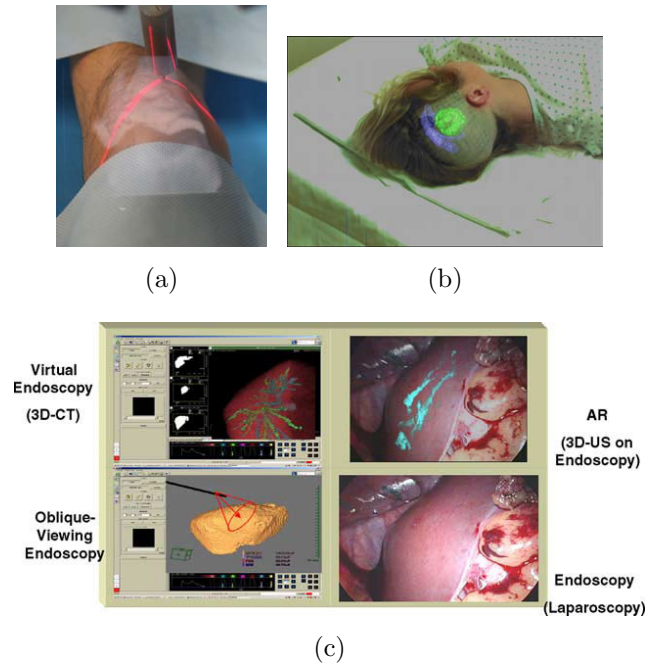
Visualization by *Augmented Reality* techniques. (a) Image of an Augmented Reality system for knee surgery, created using laser guidance techniques and 3D autostereoscopic images [Liao 2008]. (b) MRI brain image segmented and superimposition to the patient position [Grimson 1996]. (c) Integration of CT and 3D US images in Augmented Reality visualization [Konishi 2005].
